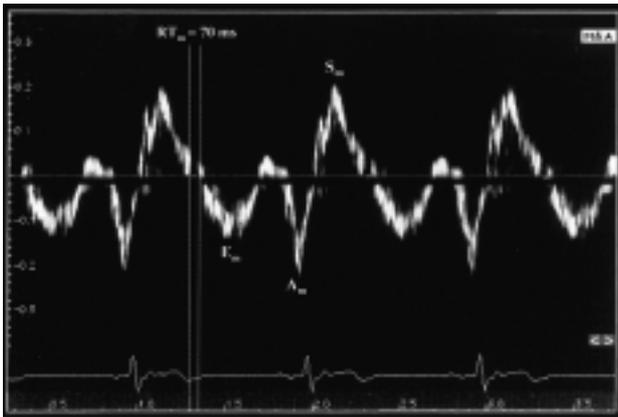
Tissue Doppler pattern of the right ventricular lateral tricuspid annulus in a hypertensive patient. The right ventricular E_n/A_m ratio is < 1 and the RT_m is prolonged (70 ms). Abbreviations as in figure 1. From Cicala et al.³¹, modified.
